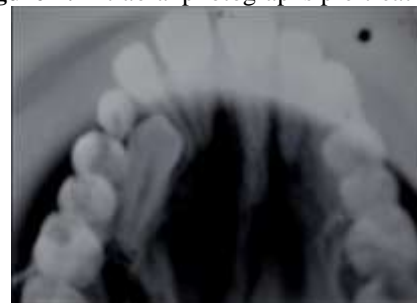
Occlusal view radiograph pre-treatment
